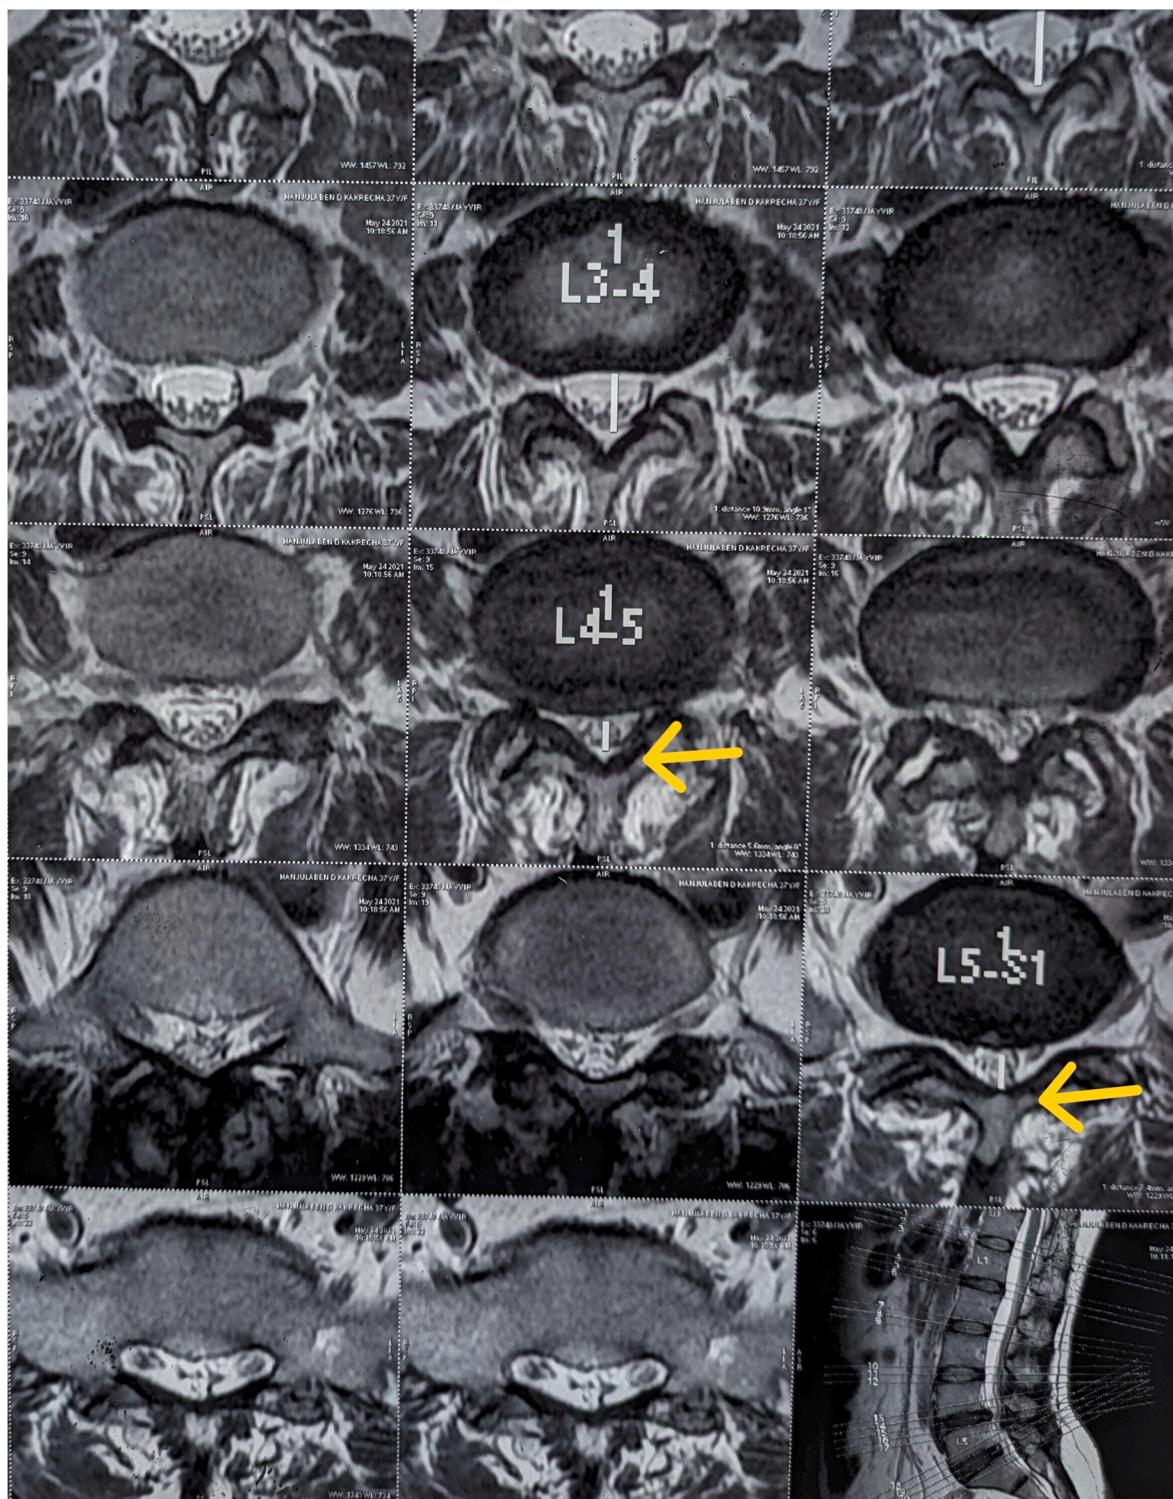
Sagittal T2-weighted MRI of the lumbar spine demonstrating postcentral protrusions of the intervertebral discs at the L4-L5 and L5-S1 levels.
